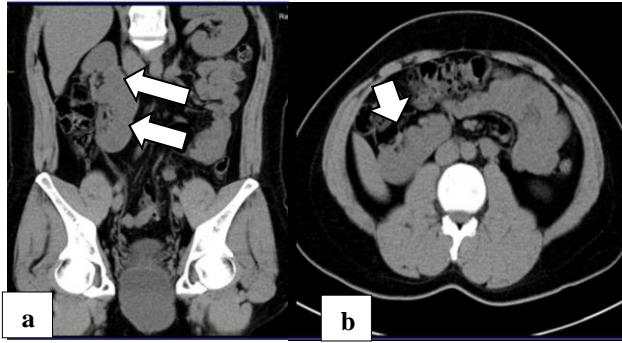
CT urography (a) coronal view: upper pole moiety (thin white arrow), lower pole moiety (thick white arrow); (b) axial view: malrotation of right kidney (white arrow).
